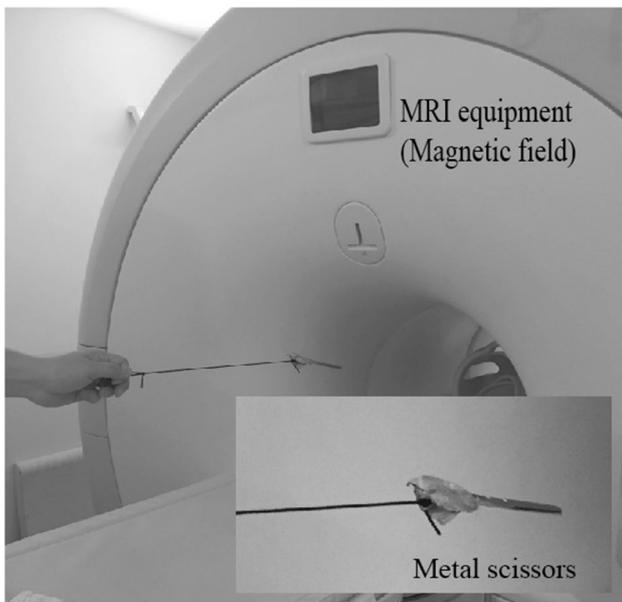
Metal scissors brought in close proximity to a magnetic resonance imaging machine. Because the machine contains a powerful magnet, magnetic objects are not permitted in the examination room
